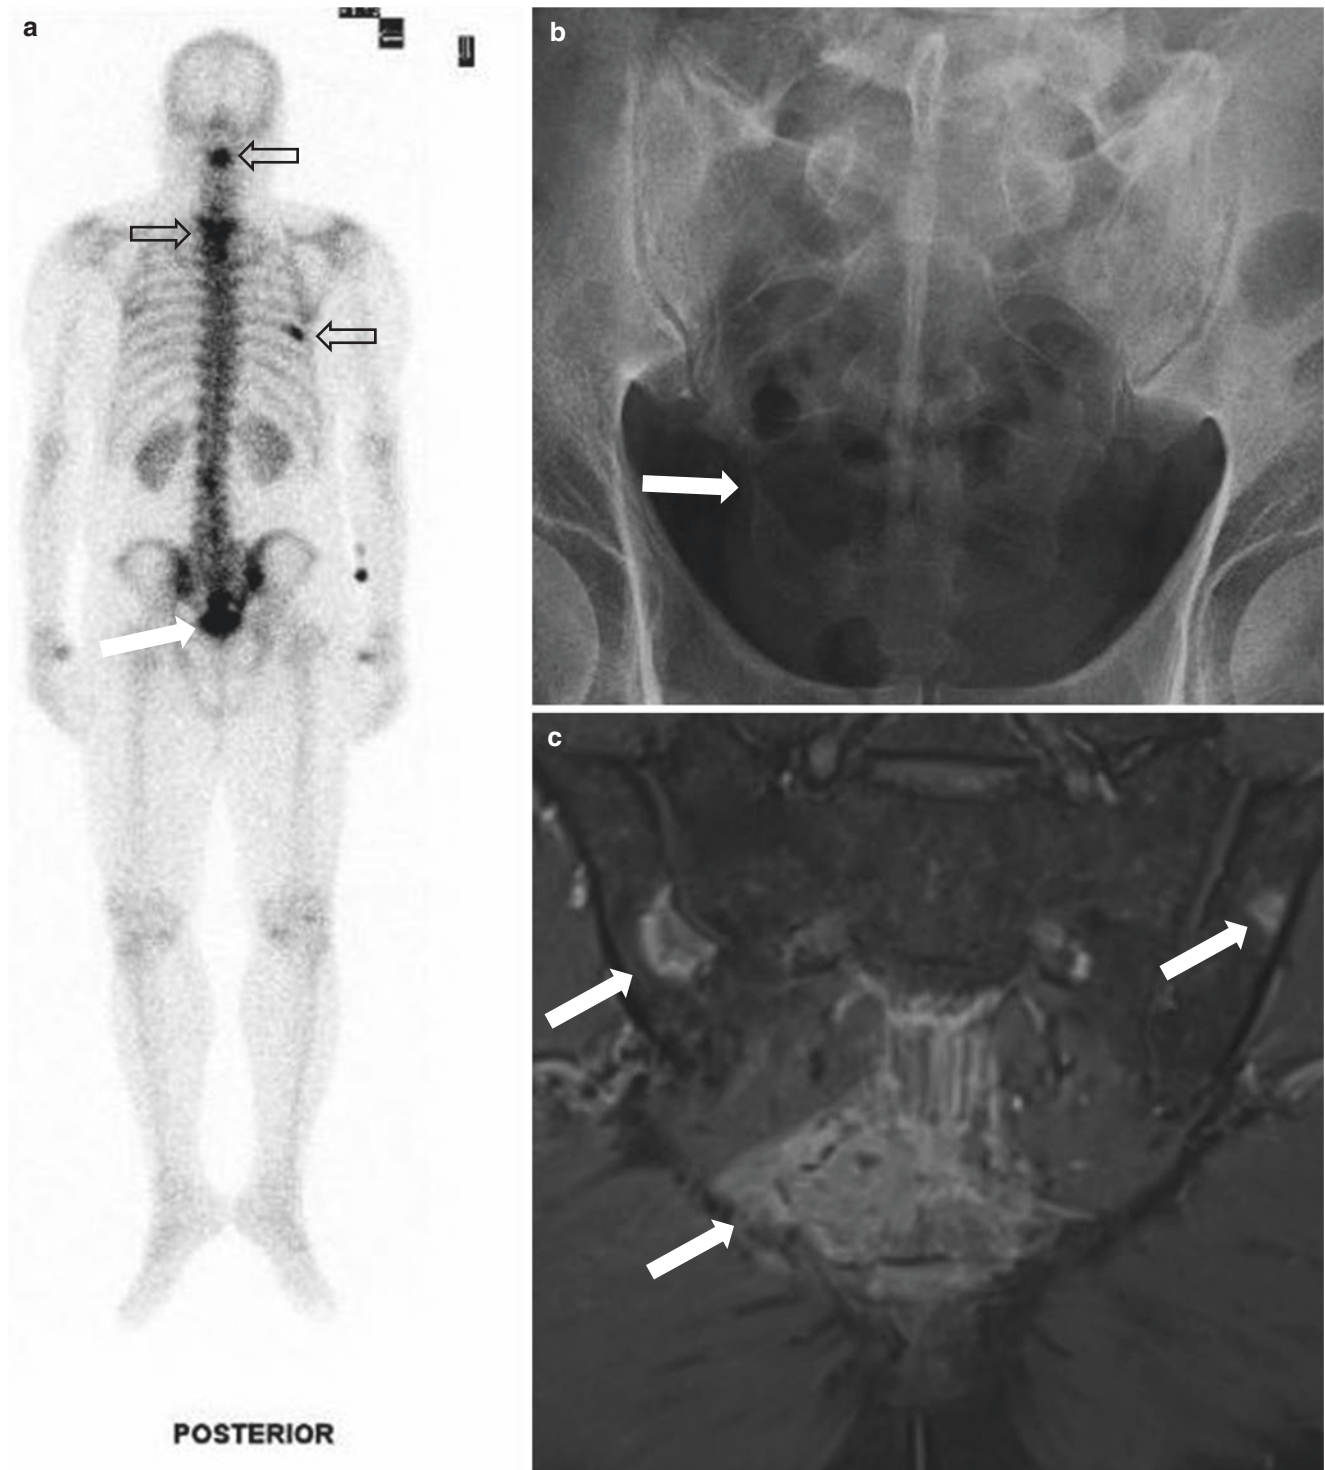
Bony metastases: (a) Bone scintigraphy, (b) pelvic radiograph, and (c) coronal T1 post contrast fat saturated images show large destructive osseous lesions seen within the sacrum and iliac bones
